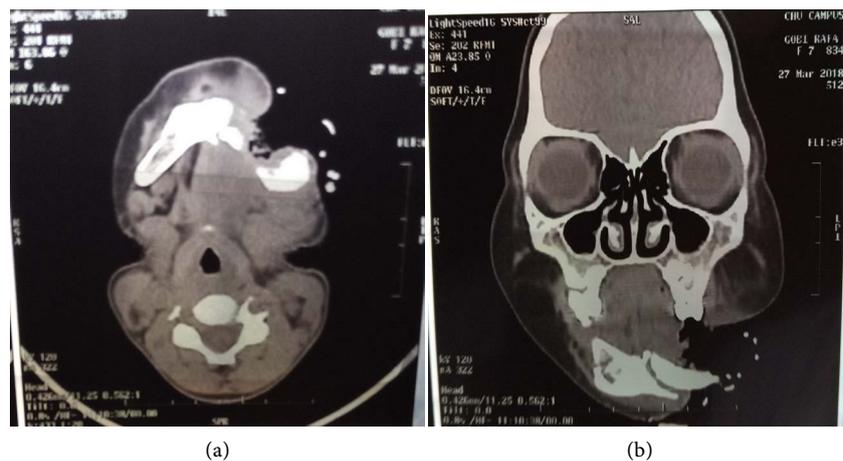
CT-SCAN showing the loss of mandibular bone.
